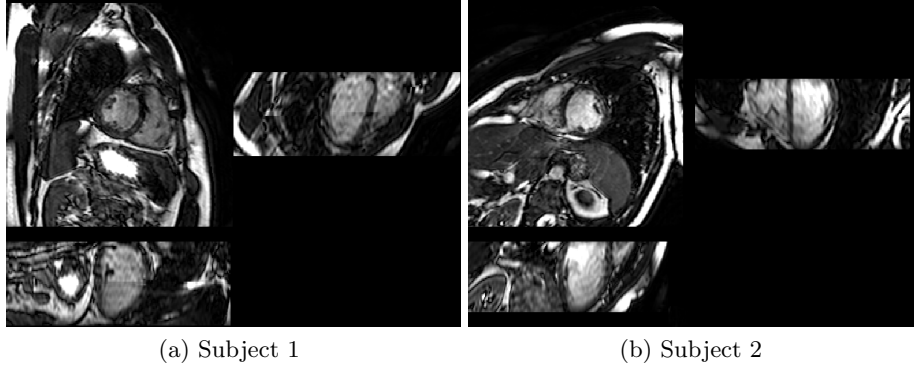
Two exemplar cardiac MR images. Three orthogonal views are shown for each subject.
